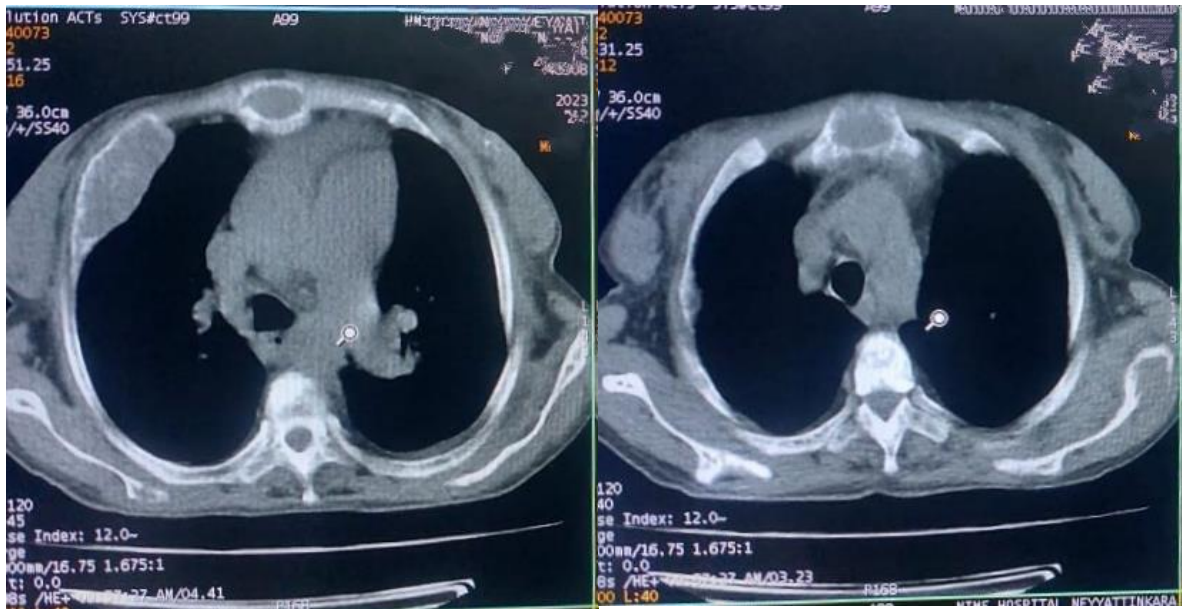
CT Scan showing expansile lytic lesions in ribs and sternum
